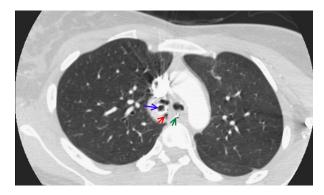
Axial view of chest computed tomography. A pneumomediastinum from the tracheal tear (red arrow), endotracheal tube in right mainstem bronchus (blue arrow), and enteric tube in esophagus (green arrow) can be seen. (Color version of figure is available online.)
